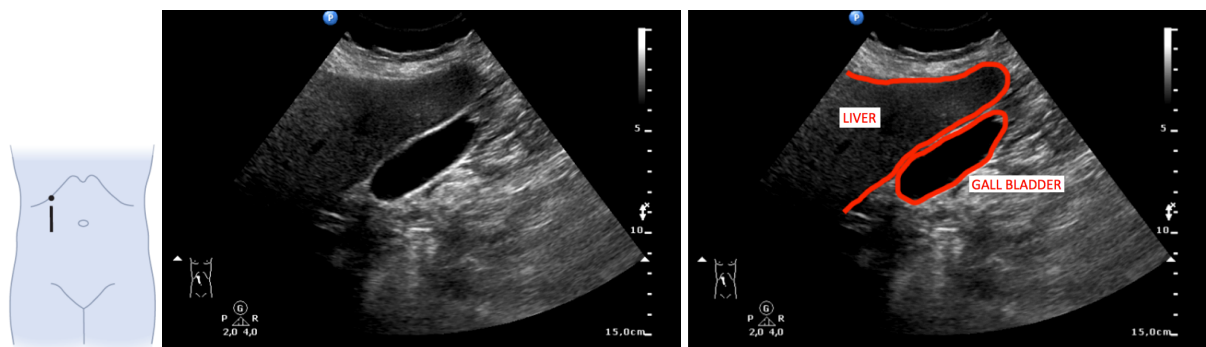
Ultrasonographic image of the gall bladder.
